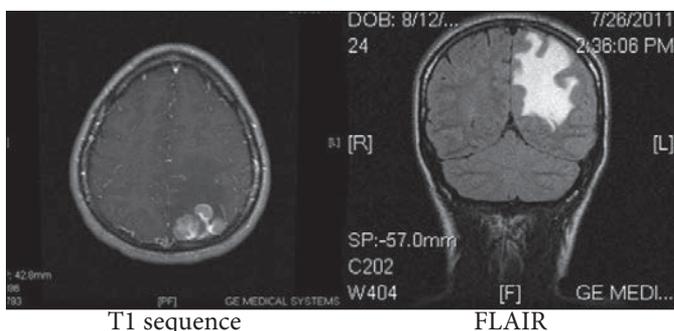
Brain MRI in a 23 year-old woman with HIV infection and primary cerebral lymphoma (left temporal and parietal lesion).
